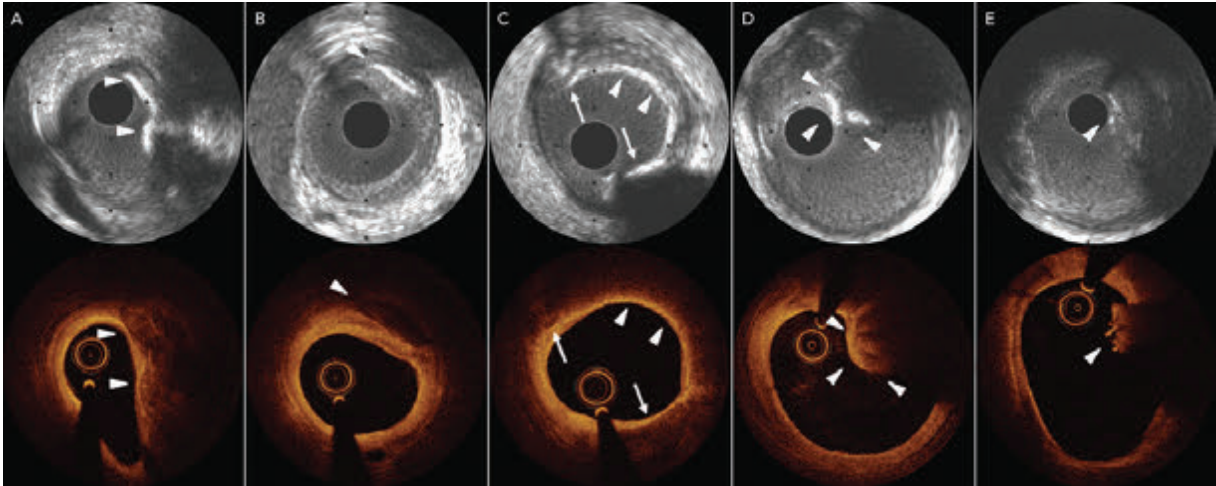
Images of calcified plaque by intravascular ultrasound (upper panel) and optical coherence tomography (lower panel). A. superficial calcium with arrowheads, B. deep calcium with arrowheads, C. IVUS reveals hyperechoic tissue without shadows (arrowheads) between spotty calcium (arrows), suggesting dense fibrous plaque or a thin layer of calcium; OCT reveals fibrous tissue with no evidence of calcium (arrowheads), D. calcified nodule (arrowheads), E. OCT depicts irregular mass protruding into the lumen (could be misinterpreted as red thrombus), IVUS shows hyperechoic mass with shadowing suggesting calcified nodule; IVUS, intravascular ultrasound; OCT, optical coherence tomography (Adapted from *Interventional Cardiology Review* 2019;14(3):164–8)
